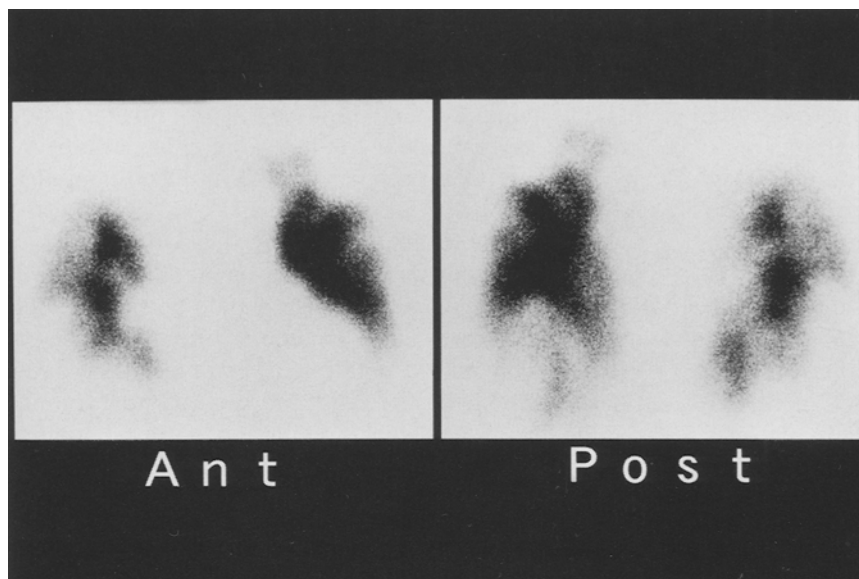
Pulmonary perfusion scintigram performed on the day of admission to the intensive care unit (ICU). Multiple perfusion defects were noted in both lungs. *Ant*, anteroposterior view; *Post*, posteroanterior view
